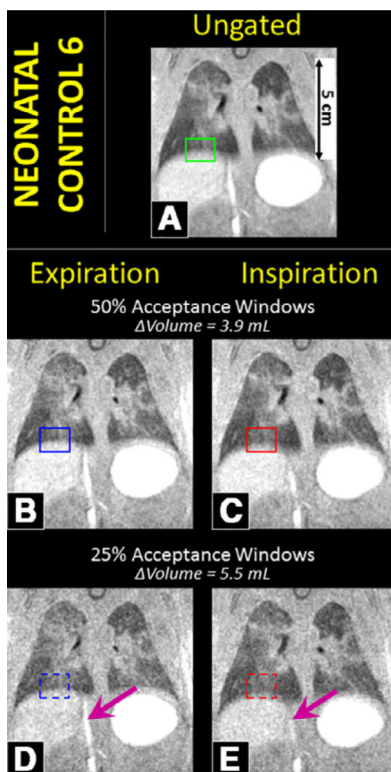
Coronal views of 3D UTE MR images in a neonatal control patient demonstrating ungated reconstructions (A) and retrospectively respiratory-gated reconstructions at 50% and 25% acceptance windows for end-expiration (B and D) and end-inspiration (C and E). The boxes indicate a region of lung-diaphragm transition, and the *arrows* indicate the inferior vena cava, the movement of which is more finely resolved in the 25%-windowed images. A tidal volume measurement—not easily assessed in infants by any clinical means—is measured via the segmentation of these images. Reprinted from Ref (19) “Retrospective respiratory self-gating and removal of bulk motion in pulmonary UTE MRI of neonates and adults,” Mara S. Higano, Andrew D. Hahn, Jean A. Tkach, Xuefeng Cao, Laura L. Walkup, Robert P. Thomen, Stephanie L. Merhar, Paul S. Kingma, Sean B. Fain, and Jason C. Woods, *Magnetic Resonance in Medicine*, 2017, Volume 77, pages 1284–1295, with permission from John Wiley and Sons. MR, magnetic resonance; UTE, ultrashort echo time. (Color version of figure is available online.)
